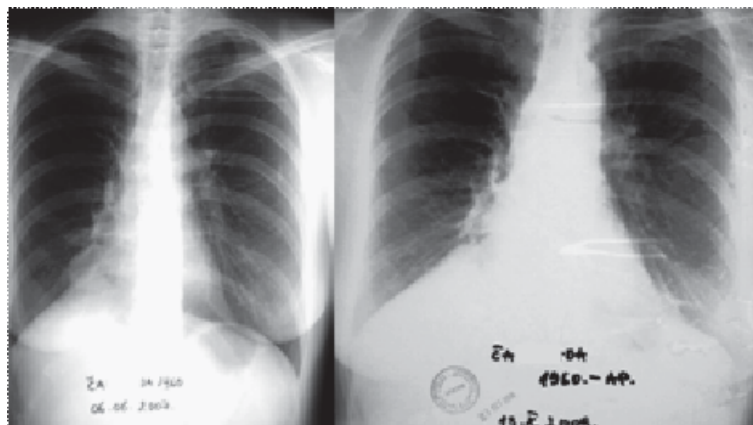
Radiography of the chest in the presented patient few years after the antibiotic therapy
